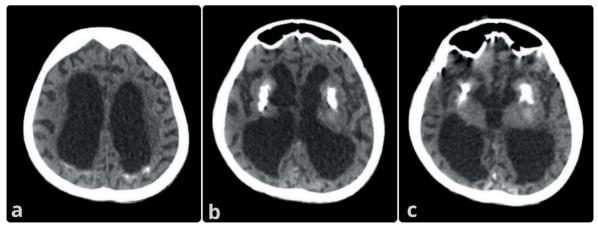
Computed tomography (CT) revealed calcification in the bilateral basal ganglia and periventricular white matter of frontal and parietal lobes (a,b,c). CT also demonstrated hemorrhage on the posterior limb of the left internal capsule and thalamus (b,c).
